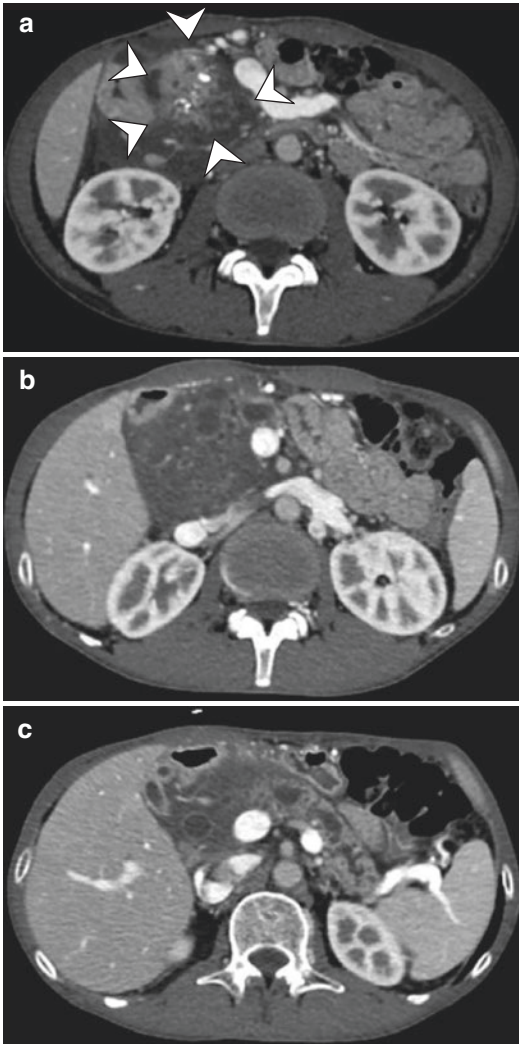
Mass-forming pancreatitis on CT. CECT axial (a, b) images show the hypo enhanced and ill-defined mass (arrow head) in the head of the pancreas. Presence of calcification in the pancreatic head suggests underlying chronic pancreatitis in this patient. There are extreme fluid accumulation in the peripancreatic region. CECT axial (c) image shows the pancreas is reduced in size in the body-tail with the irregular dilatation of the main pancreatic duct
